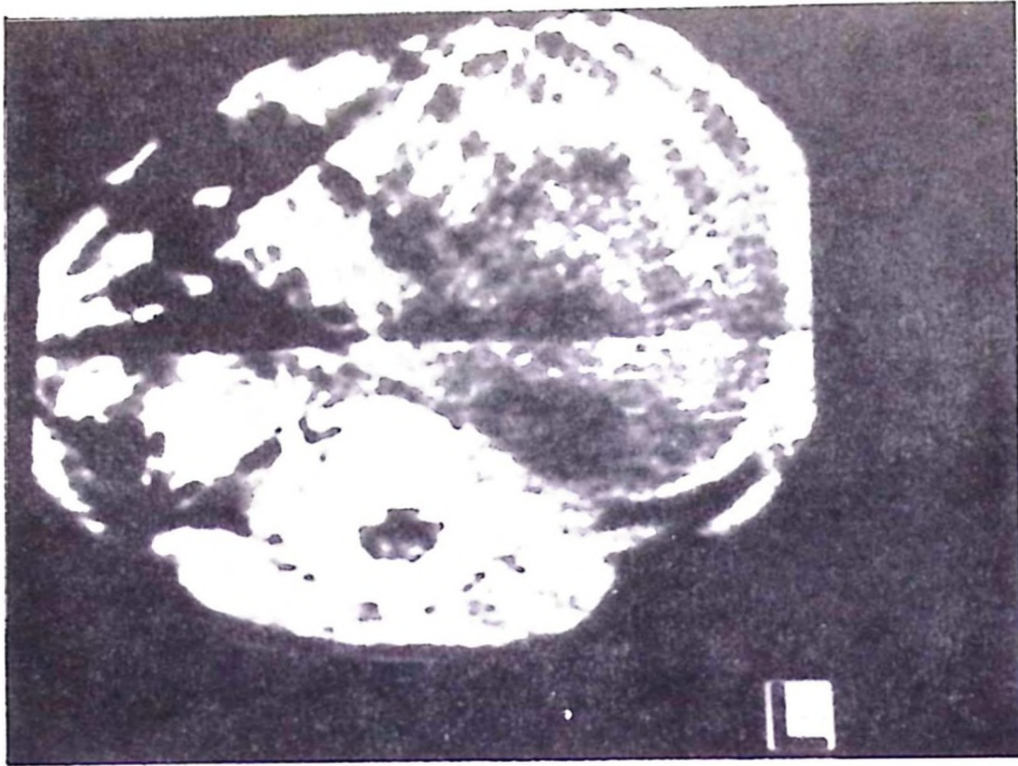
CT scans of abdomen showed a large solid mass with focal cystic areas in the left kidney.
